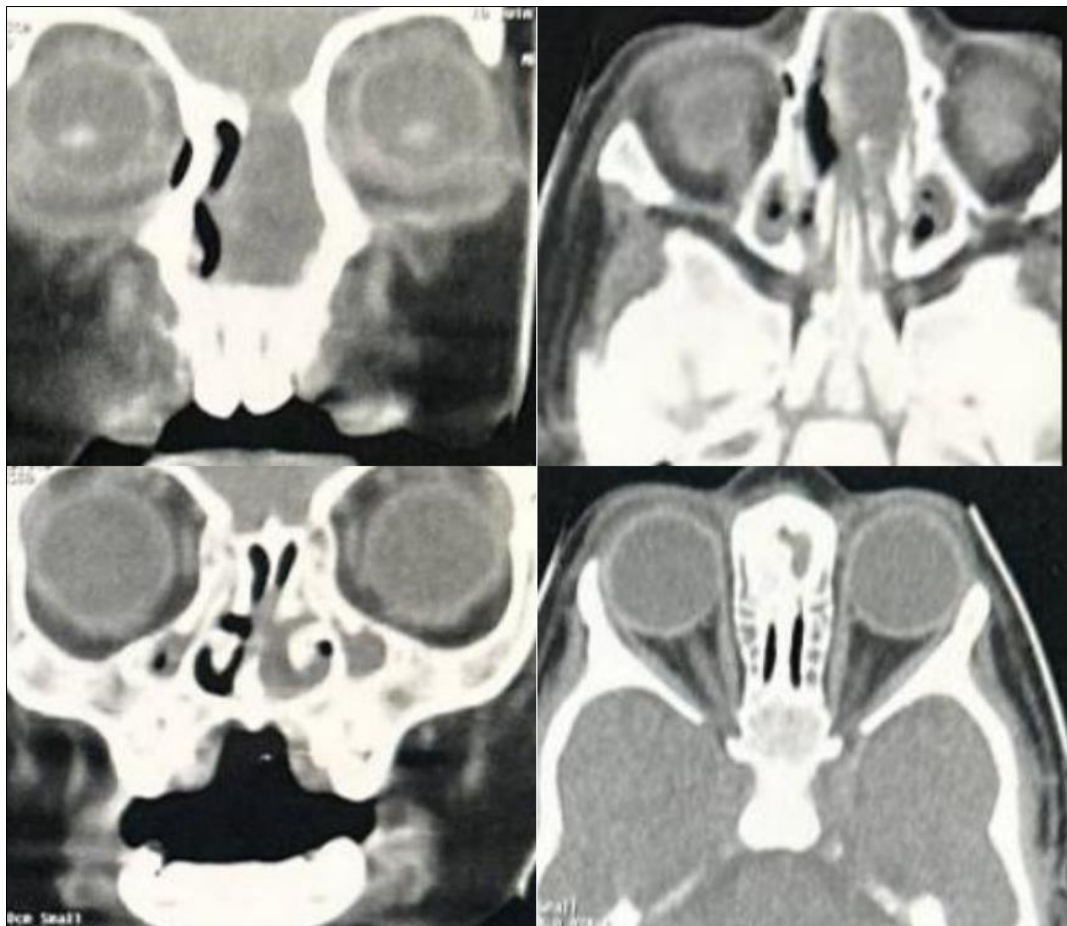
CT scan showing left ethmoidal meningoencephalocele and associated anatomical features
